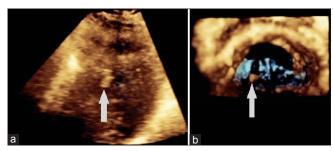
The left ventricle mass (white arrow) is observed on real-time three-dimensional transesophageal echocardiography imaging through virtual left ventriculotomy in frontal plane with high gain (a) and in virtual short-axis plane with low gain (b). It can be easily distinguished from both papillary muscles by making fine adjustments in gain and compression
